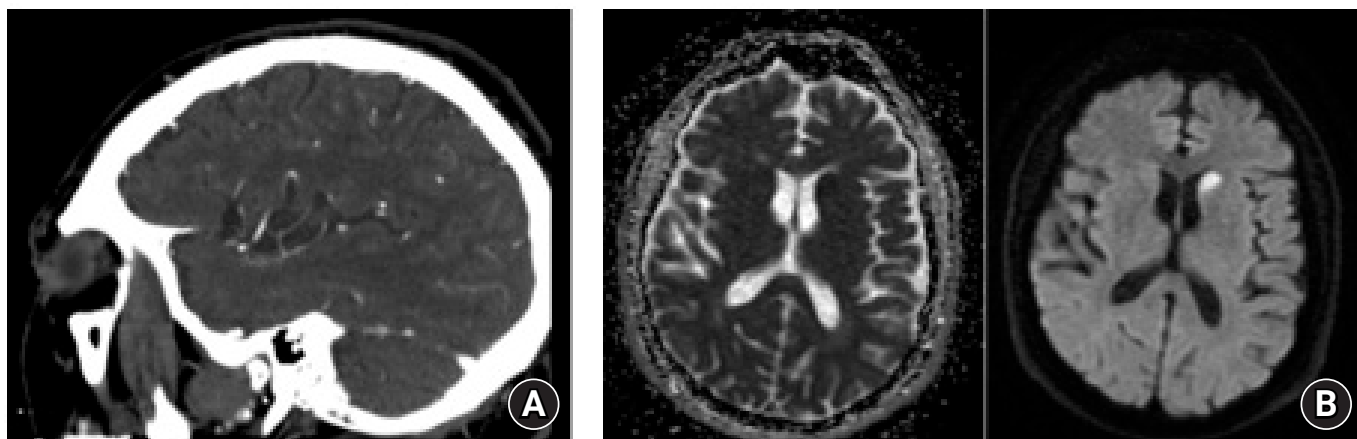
(A) Computed tomography imaging from primary stroke center, demonstrating M2 lesion. (B) MRI images (left: apparent diffusion coefficient and right: diffusion weighted image) at comprehensive stroke center, after onset of hemichorea-hemiballismus symptoms. MRI: Magnetic resonance imaging.
